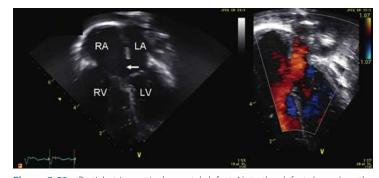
Partial atrioventricular septal defect. Note the defect *(arrow)* on the apical four-chamber view *(left)* in the inferior portion of the atrial septum. A left-to-right atrial shunt is shown on the color Doppler image *(right)*.
